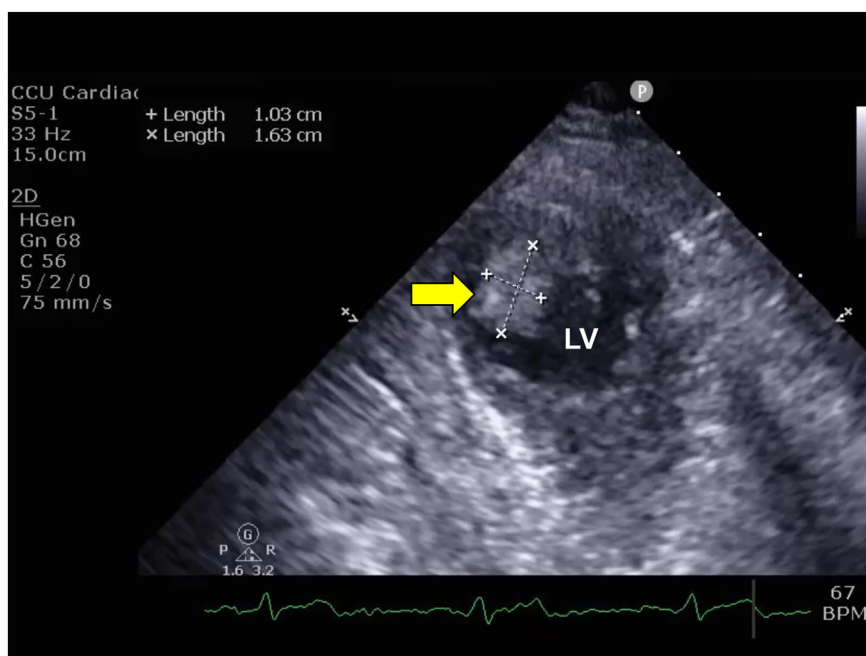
Two-dimensional TTE (day 13), parasternal short-axis view at the apical level, demonstrates an intraventricular thrombus attached to the left ventricular wall (arrow). LV, Left ventricle.
